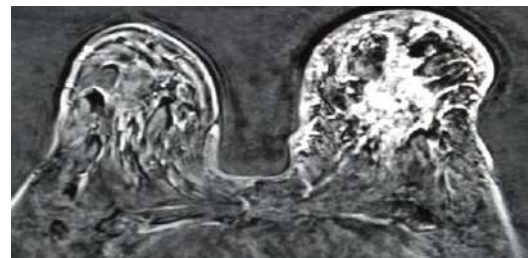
Axial section of T2W MRI breast showing ill defined hyperintense lesions in left breast parenchyma with diffuse edematous changes
